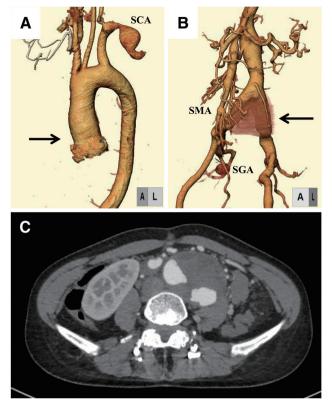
Computed tomography images showing vascular abnormalities. (A) Dilatation of the aortic root (arrow) and left SCA aneurysm. (B) AAA (arrow), dilation of the SMA, right SGA aneurysm. (C) Axial image of AAA. AAA: abdominal aortic aneurysm; SCA: subclavian artery; SMA: super mesenteric artery; SGA: superior gluteal artery
